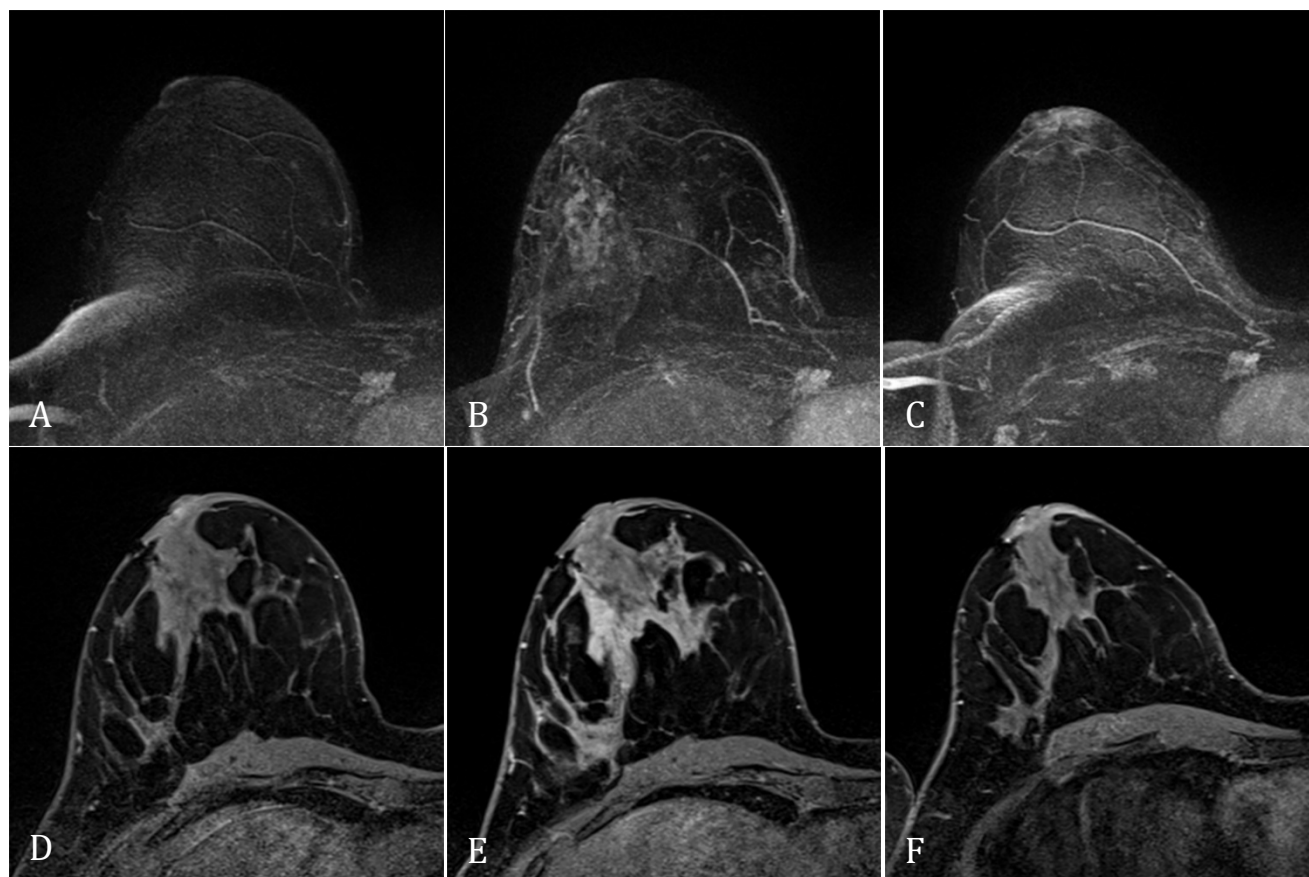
High-risk patient (no known mutation) with S/P left mastectomy for breast cancer in 2013 at age 35. Regular surveillance MRI's in May 2015 receiving adjuvant endocrine treatment with tamoxifen (A, D), March 2016 two months after discontinuation of tamoxifen to prepare for a possible pregnancy (B, E), and May 2017 after reinitiation of tamoxifen treatment (C, F). A temporary increase in BPE can be seen while the patient is off tamoxifen (B, E).
